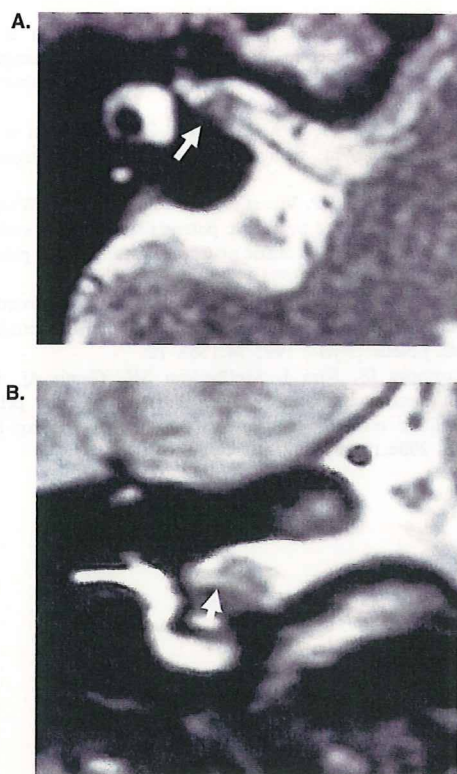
T2-weighted MRI without contrast medium. White arrows indicate the tumor. (a) Axial view; (b) coronal view.
